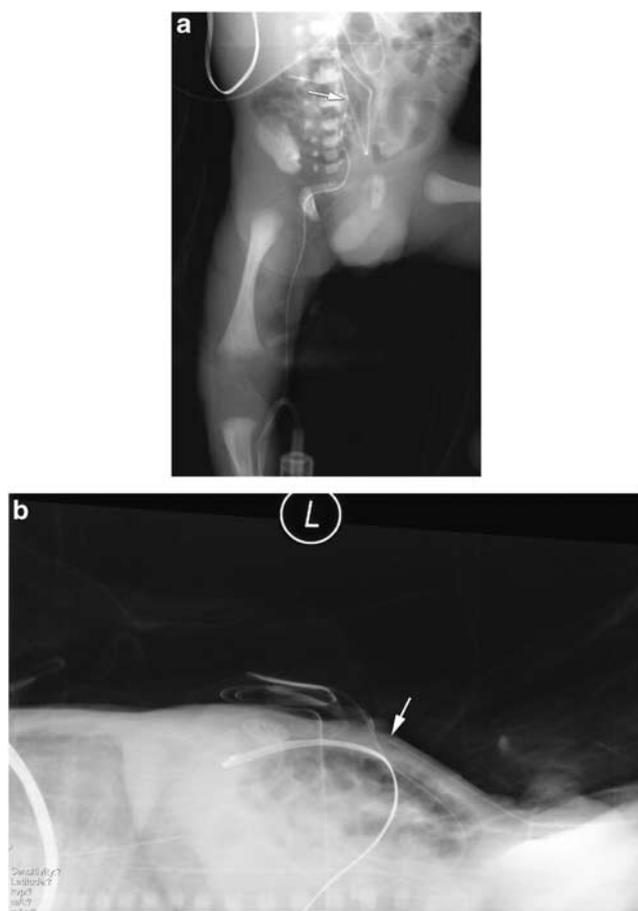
(a) Anteroposterior radiograph of the abdomen. The arrow is pointing to the tip of the PICC at L5. (b) Lateral radiograph. The arrow is pointing to the tip of the PICC.
